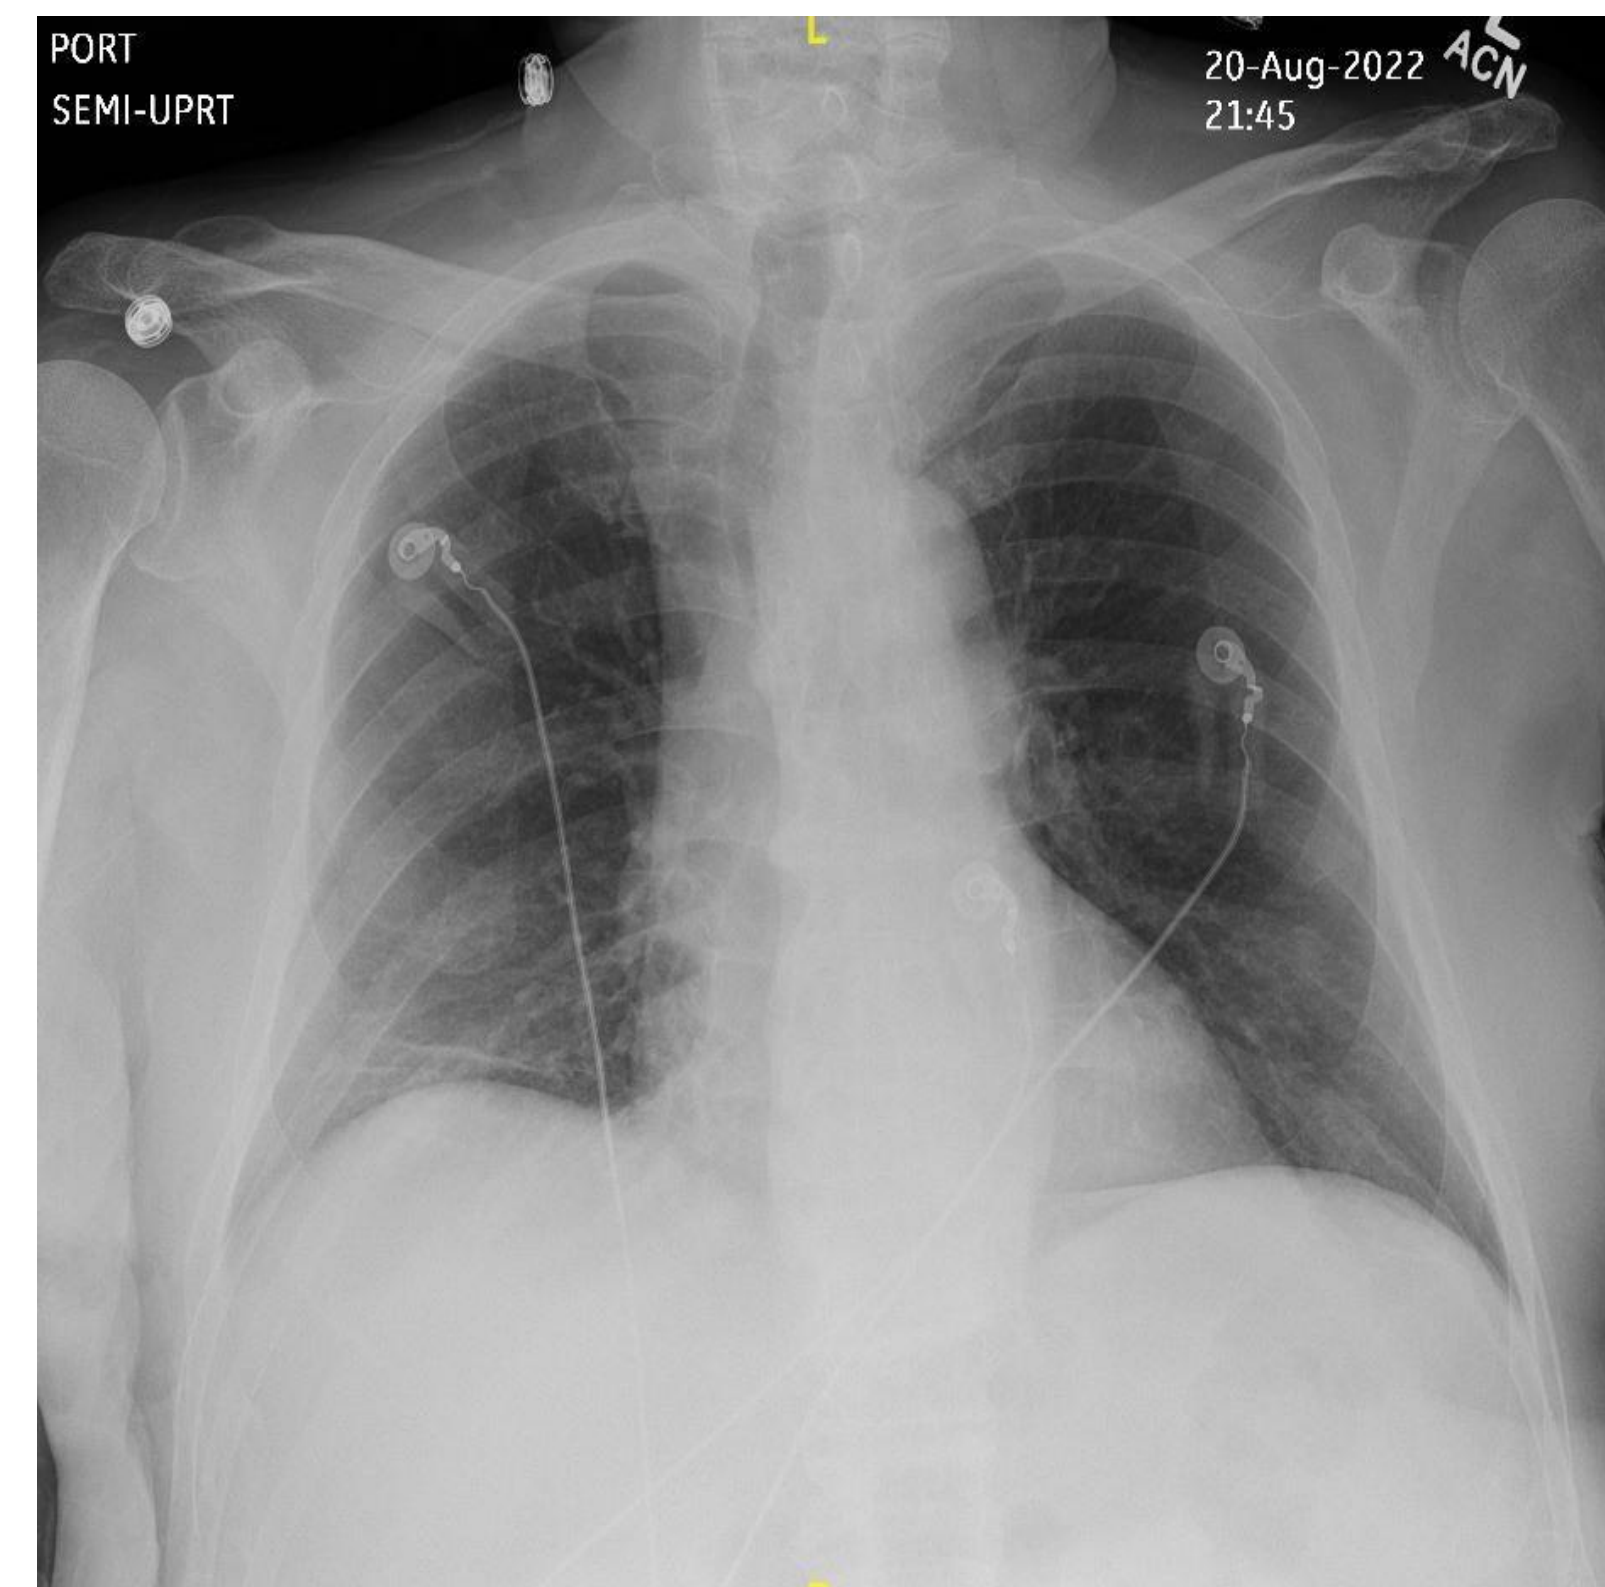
Chest x-ray on day of admission.
